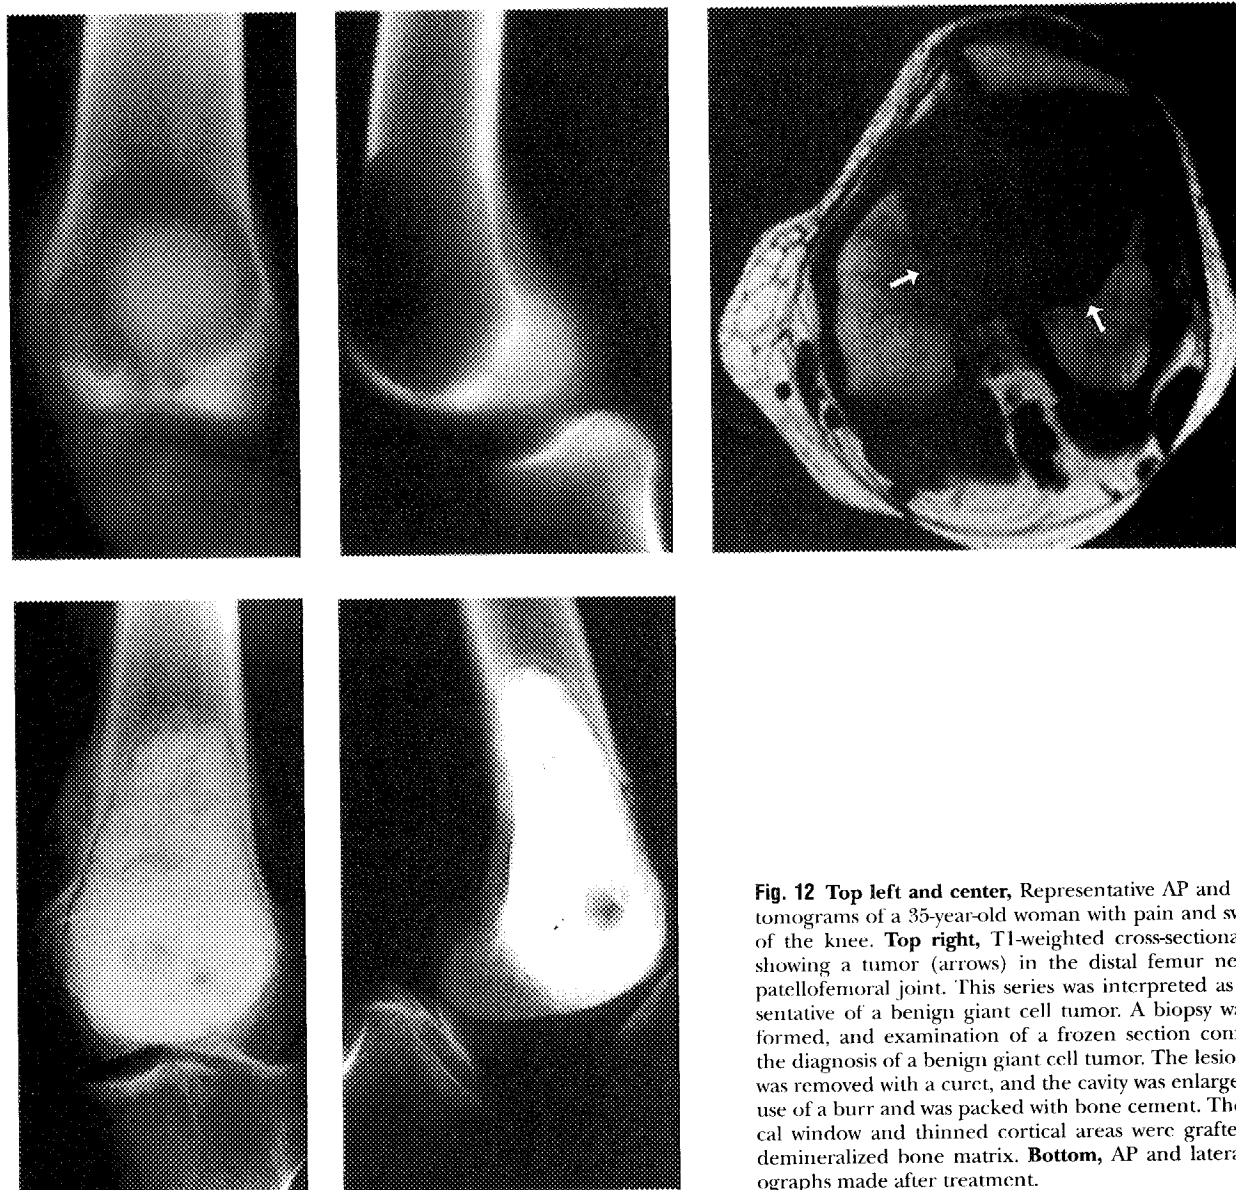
Top left and center, Representative AP and lateral tomograms of a 35-year-old woman with pain and swelling of the knee. Top right, T1-weighted cross-sectional MRI showing a tumor (arrows) in the distal femur near the patellofemoral joint. This series was interpreted as representative of a benign giant cell tumor. A biopsy was performed, and examination of a frozen section confirmed the diagnosis of a benign giant cell tumor. The lesion then was removed with a curet, and the cavity was enlarged with use of a burr and was packed with bone cement. The cortical window and thinned cortical areas were grafted with demineralized bone matrix. Bottom, AP and lateral radiographs made after treatment.
